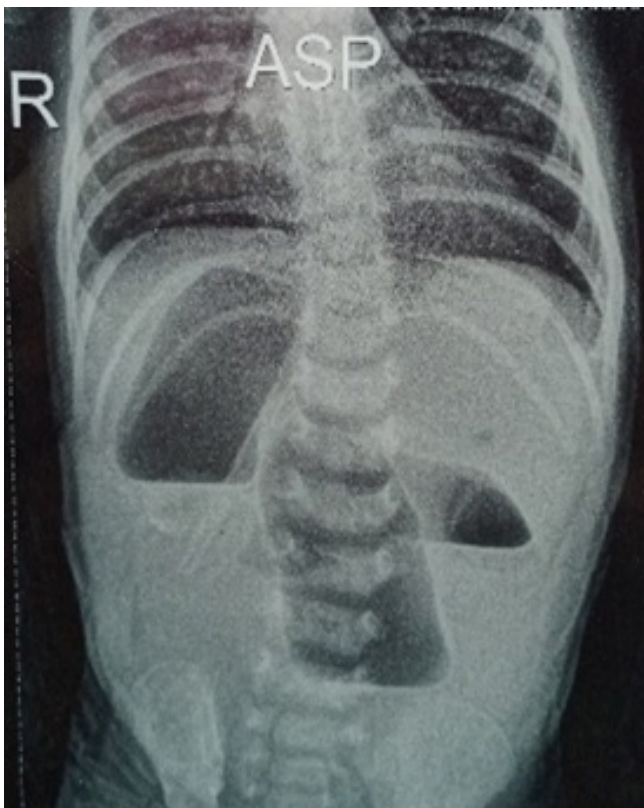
Plain abdominal X-ray.
